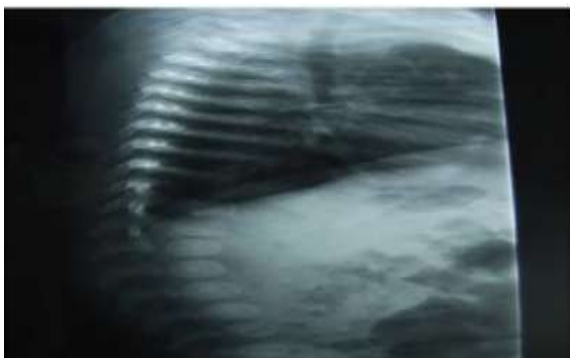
lateral chest radiograph: slender ribs.
